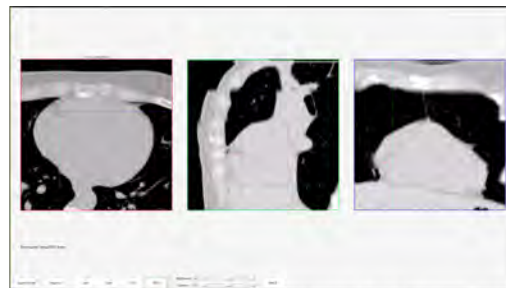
Cardiac CT, with crosshairs marking a single point in the right coronary artery in axial, sagittal, and coronal planes, as viewed in our SWCS tool workstation
